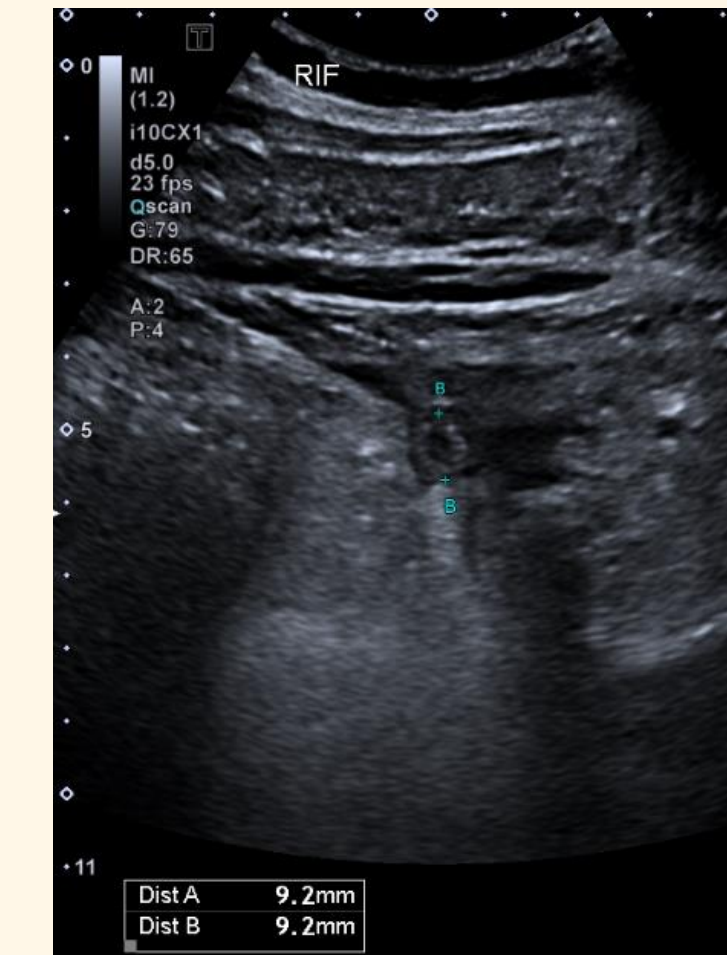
Ultrasound image of appendiceal diameter of 9.2mm suggesting acute appendicitis
